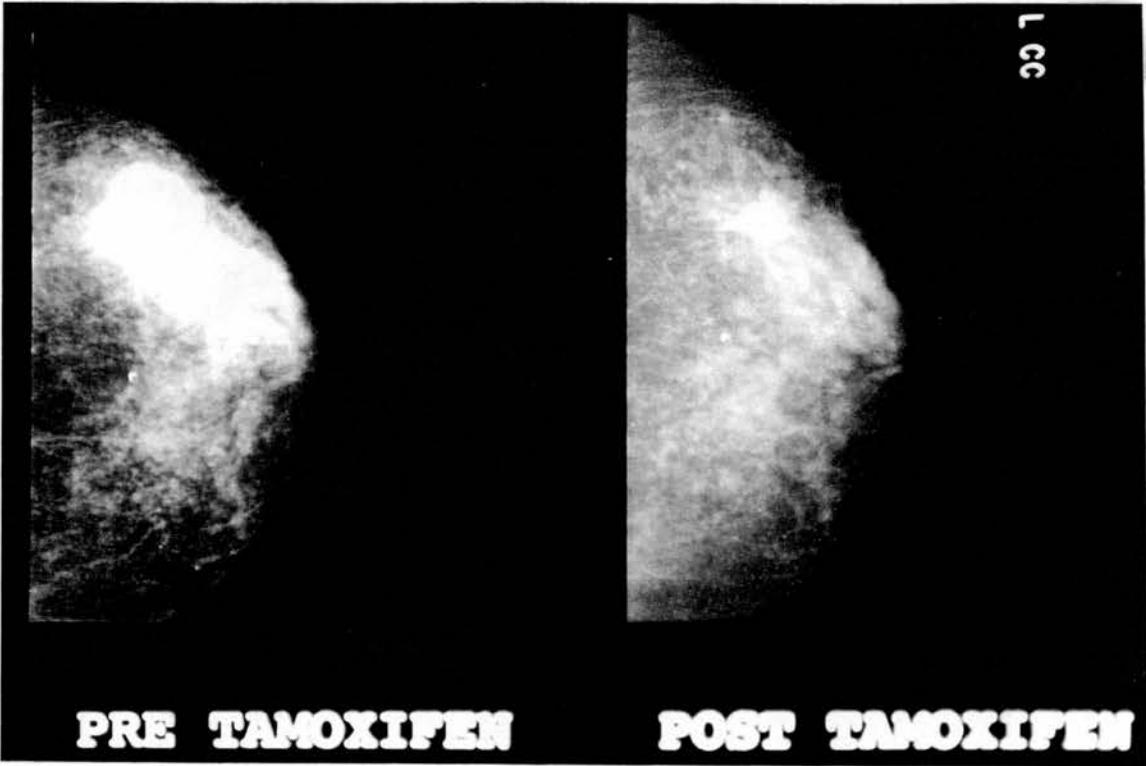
shows reproductions of mammograms performed on the same responding patient whose ultrasound scans are shown in Figure 13.7. The X-Rays were performed before and after three months treatment with tamoxifen and demonstrate the comparative ease of tumour measurement by ultrasound.
